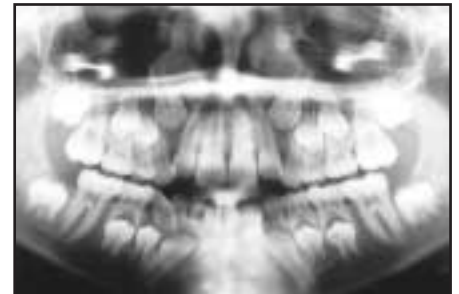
Orthopantomogram radiograph showing the complete transposition of 2/ with 3/. N.B. The 54/ are developing in their normal positions.
